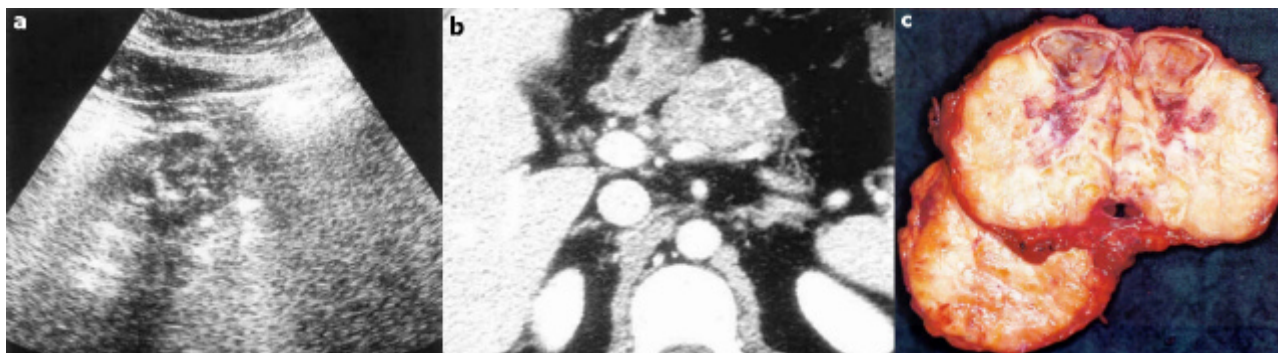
Case 4. US revealing a round, well-defined, non-homogeneous mass of the pancreatic body, 5x4 cm in diameter, with a thin capsule and multiple central foci of calcifications (a.). A computed tomography scan confirmed the ultrasound findings (b.). A central pancreatectomy was performed and the mass appeared as a solid and cystic lesion (c.). (Image c. is presented in another contribution by the same authors, published in these Proceedings [30], in order to describe aspects not related to those reported here)
